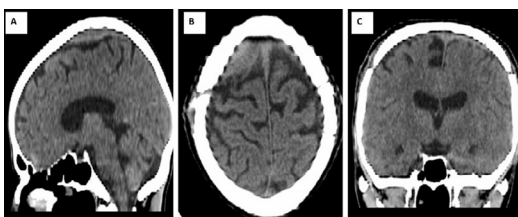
CT Head at the Time of Discharge.
